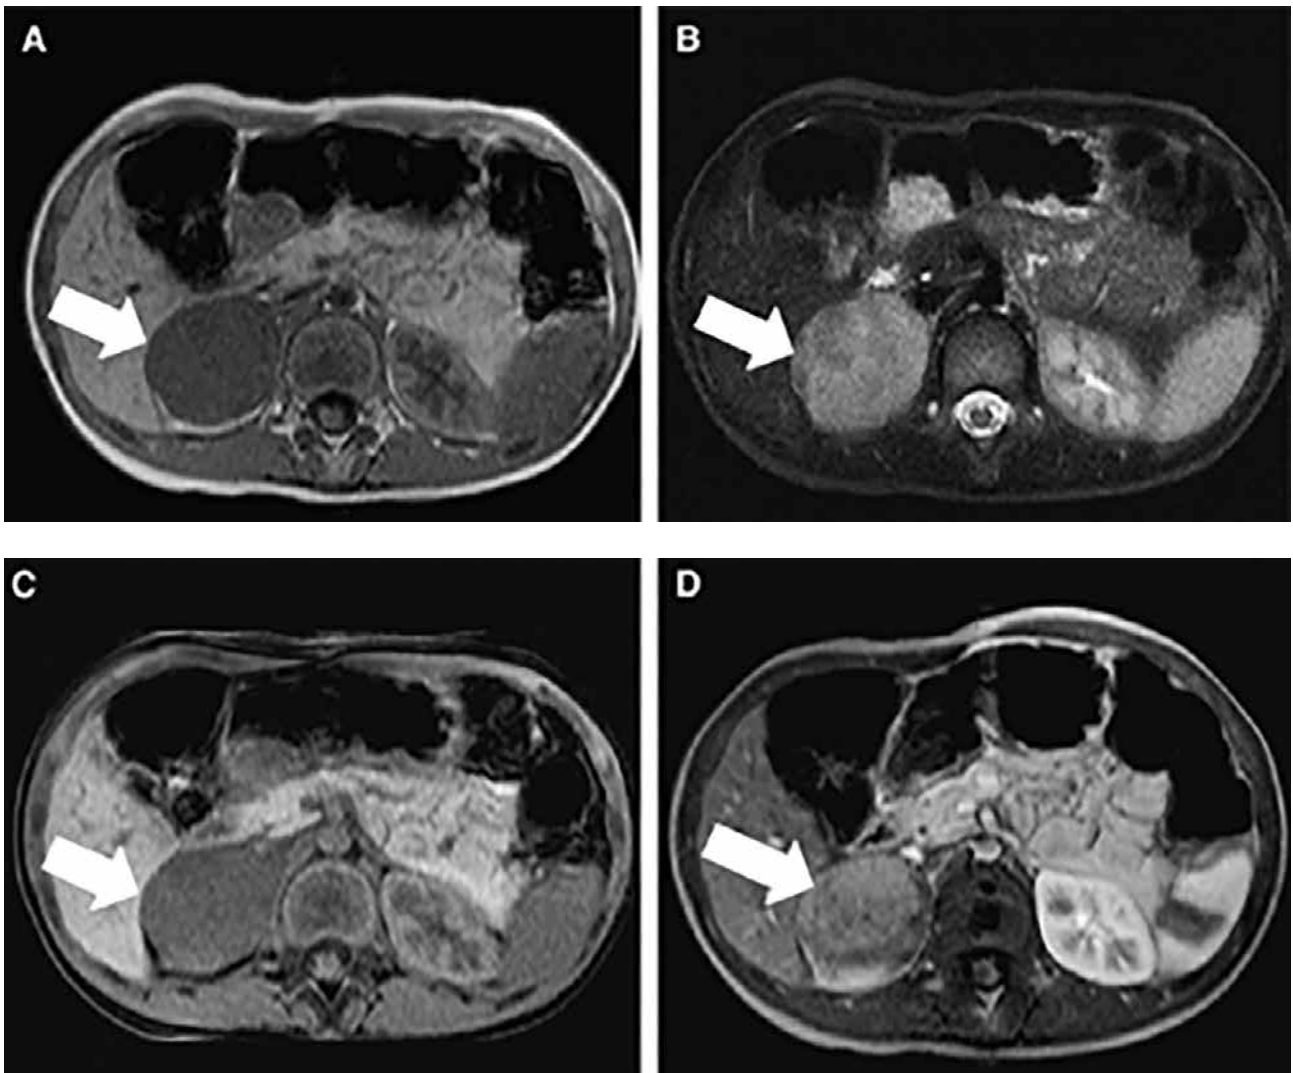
Ganglioneuroma (arrow) of the right adrenal gland is demonstrated as homogeneous and hypointense on MRI T1W image (A), heterogeneous and hyperintense on T2W image (B), homogeneous and isointense on fat-suppressed T1W image (C). After administration of the contrast agent, a slight and heterogeneous enhancement is observed (D). (Qing Y, Bin X, Jian W, Li G, Linhui W, Bing L, Huiqing W, Inghao S. Adrenal ganglioneuromas: a 10-year experience in a Chinese population. *Surgery* 2010; 147(6): 854-860)
